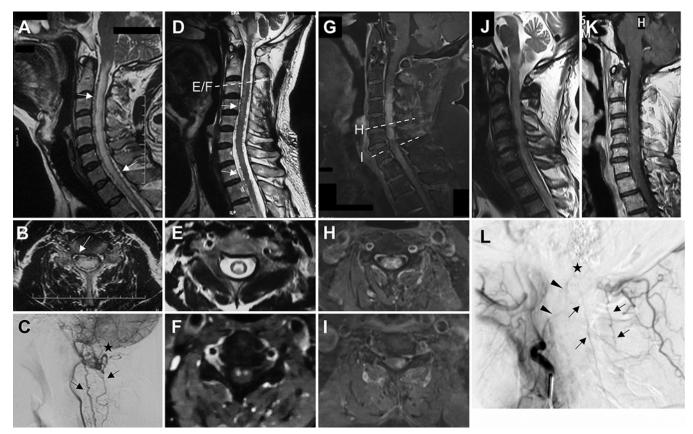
Diverse imaging findings before surgery. A-C: Images with typical imaging features obtained in a middle-aged male who reported lower-extremity weakness and difficulty with urination and defecation. Sagittal and axial T2-weighted MR images showing multisegment (A) and transverse (B) intramedullary hyperintensity was found with spinal cord surface abnormal vascular shadowing. An angiogram showed that the fistula was fed by the dural branch of the VA and drained along the ventral and dorsal spinal cord (C). D-F: Images obtained in a middle-to-older-aged male who reported nausea, numbness in both hands, and lower-limb weakness. Sagittal T2-weighted image showing involvement of the medulla and spinal cord were (D). Axial images showing gray matter T2 hyperintensity (E) and T1-weighted Gd enhancement of the anterior horn (F). G-I: Images obtained in a patient in his mid-70s who reported neck and back pain and paresthesia of the right upper limb. Sagittal Gd-enhanced T1-weighted image revealing a "missing-piece" sign, that is, one nonenhancing area within a long segment (> 2 vertebrae) of enhancement (G). Axial images of different segments showing irregular enhancement (H and I). J-L: Images obtained in a patient in his 60s with neck and back pain and appendicular weakness at 1 week who was misdiagnosed with acute myelitis. Sagittal T2-weighted image showing hyperintensity and swelling of the spinal cord and medulla oblongata (J). Gd-enhanced image examination showing a few abnormal vessels in the ventral spinal cord (K). However, the neurologist ignored the abnormality, and the patient developed paralysis and urinary incontinence due to methylprednisolone pulse therapy. Subsequent angiography revealed a fistula at the jugular foramen region fed by the APA and drainage into the spinal cord (L). White and black arrows indicate abnormal draining veins. Stars indicate abnormally connecting arteries and veins. Arrowheads indicate arterial feeding vessels. Dashed lines indicate the location of the corresponding axial images.
